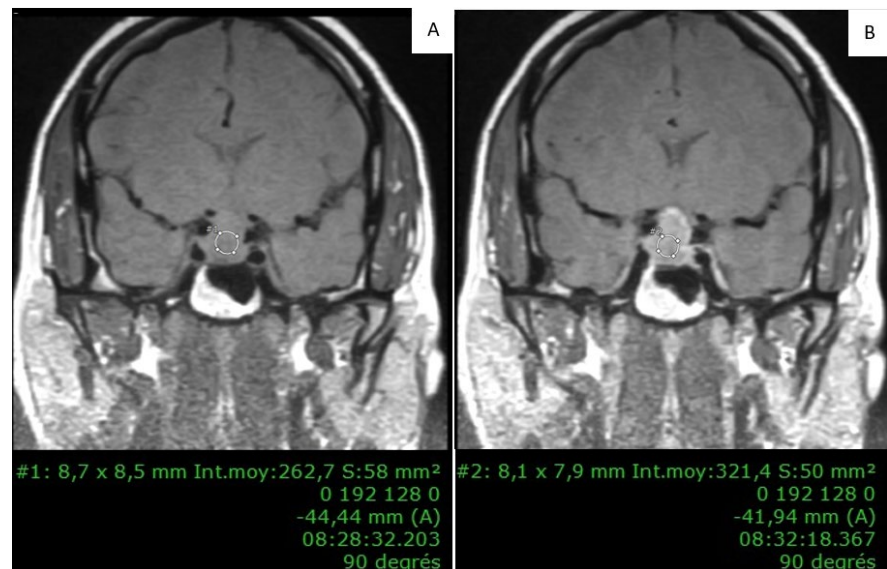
T1-weighted dynamic contrast-enhanced MRI with gadolinium injection, showing a sellar lesion with suprasellar extension, in a 37-year-old female patient presenting with visual disturbances and amenorrhea, showing a sellar and suprasellar mass. ROI pre-injection (SI pre) = 262.7 (A) and ROI 4 minutes after injection (SI post) = 321.4 (B). The calculated enhancement ratio is 22.34%, consistent with a weak enhancement.
